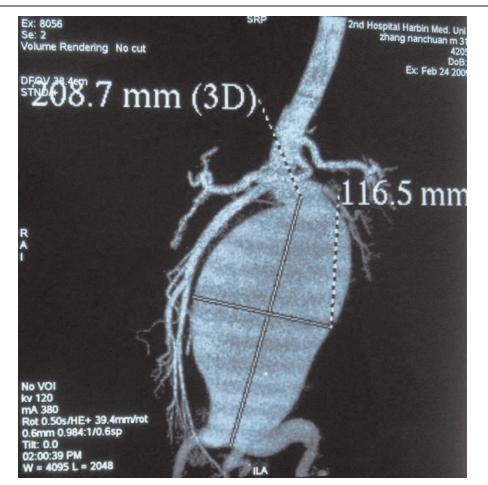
Computed tomography angiography (CTA) of abdominal aorta revealed a giant abdominal aortic aneurysm (AAA), approximately 20 × 11 cm in diameter.
